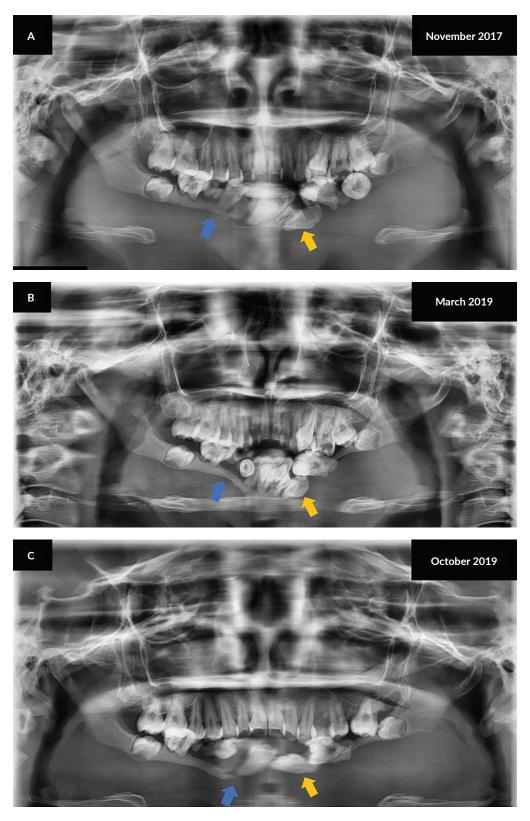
Series of panoramic x-rays (November 2017 – October 2019). Panoramic x-rays showing the lysed left angle of the mandible and progressive tapering of the right body of the mandible at midline (*blue arrows*) with progression of dental malalignment and loss of the mandibular teeth (*orange arrows*).
